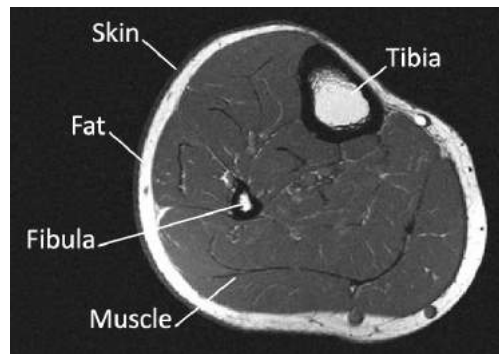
MRI Axial image for human leg showing structures including skin, fat, muscles, tibia and fibula.
